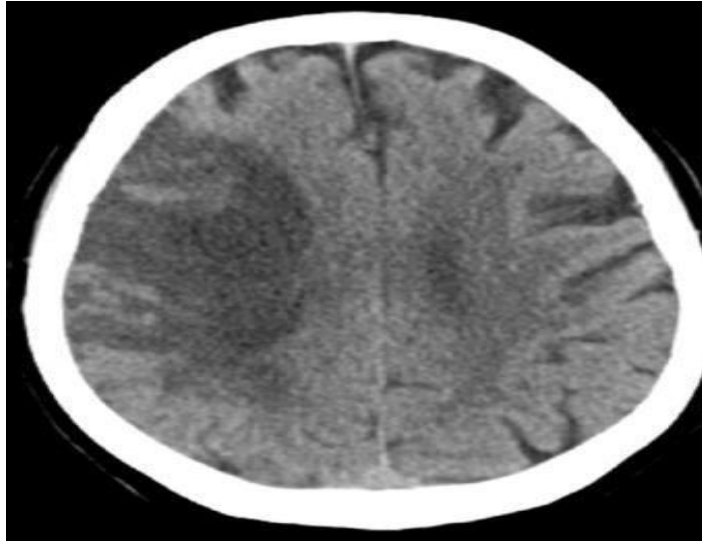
Follow up CT brain with right parietal infarction.
